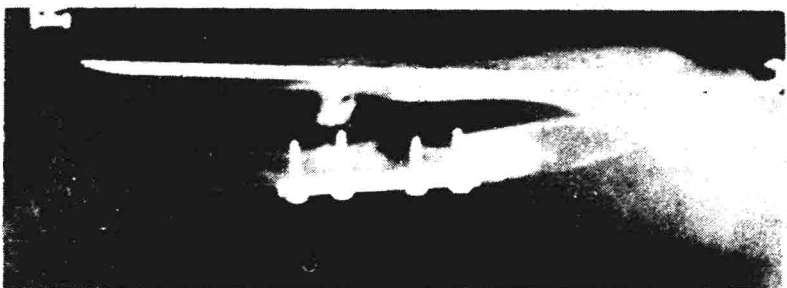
a*, Computerized tomography (CT) reveals irregular margins of L2 after a crush fracture. No spinal stenosis present. *b*, Technetium 99 isotope uptake in a pathological fracture of L3 body. *c*, An arteriogram reveals an aneurysm of the femoral artery following a femoral shaft fracture in an 8-year-old girl, 1 year previously. *d*, A xerox film showing the soft tissues and bony trabeculae, in this case a chronic thickening of the Achilles tendon in a badminton player.
